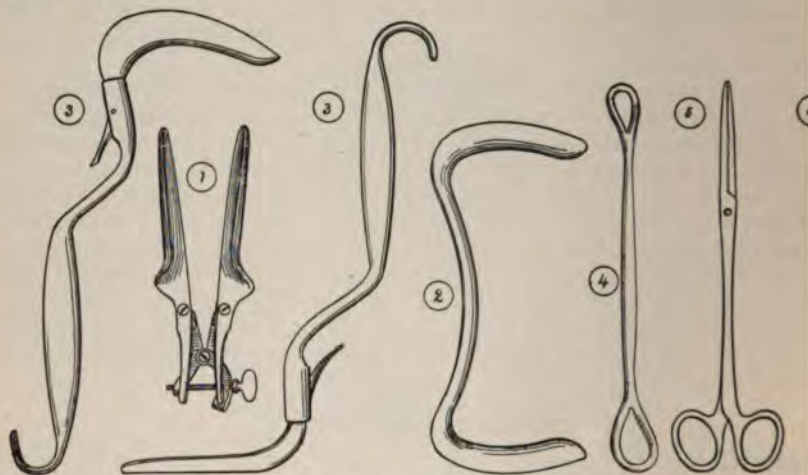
INSTRUMENTS FOR INDIRECT INSPECTION OF THE VAGINA (page 231).
